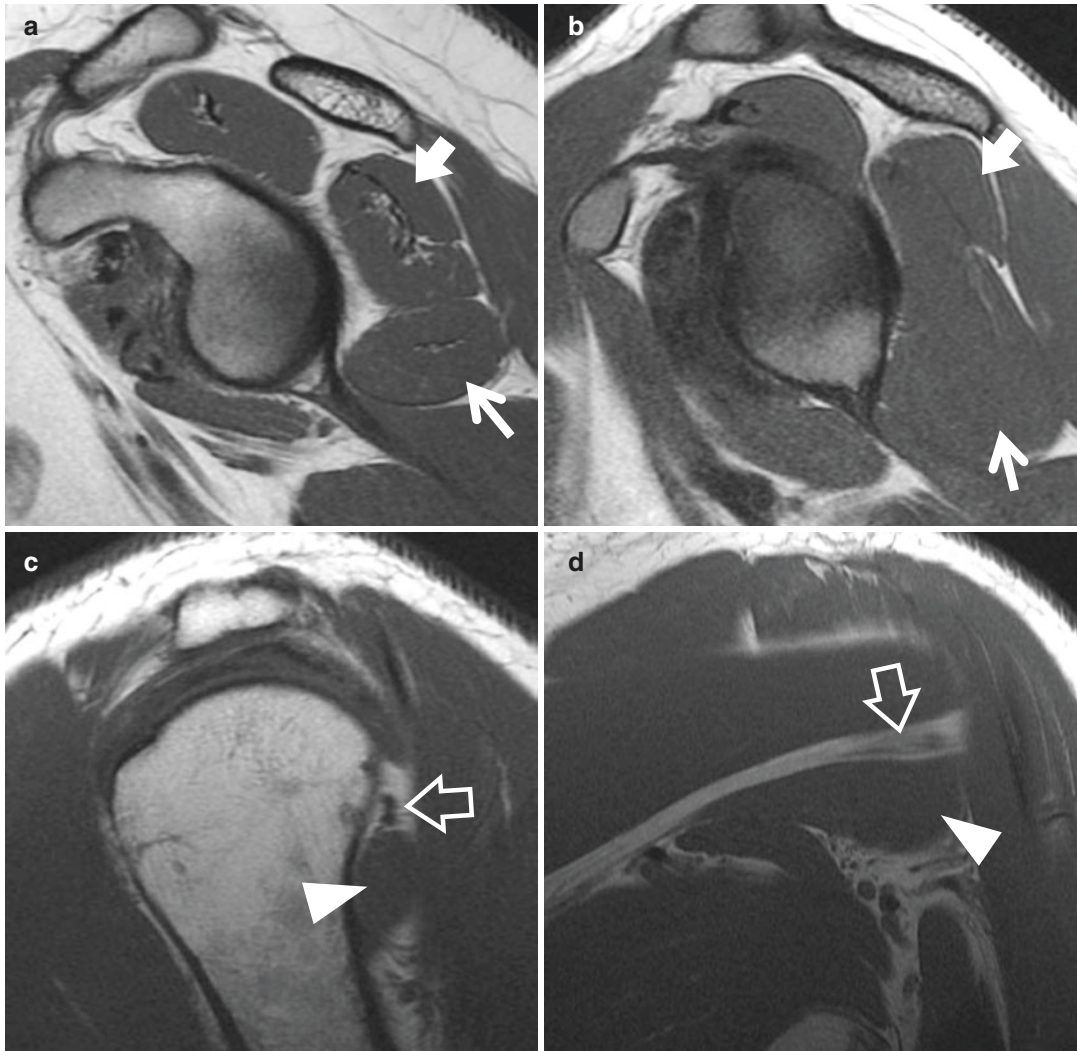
Anatomic variations and pathology of the teres minor muscle. (a) Sagittal oblique T1-weighted image of a 21-year-old woman with well-delineated infraspinatus (thick arrow) and teres minor (thin arrow) muscles. (b) Sagittal oblique T1-weighted image of a 23-year-old woman with an indistinct boundary between the infraspinatus (thick arrow) and teres minor (thin arrow) muscles, indicating a hypoplastic fascial septum. (c and d) Sagittal
